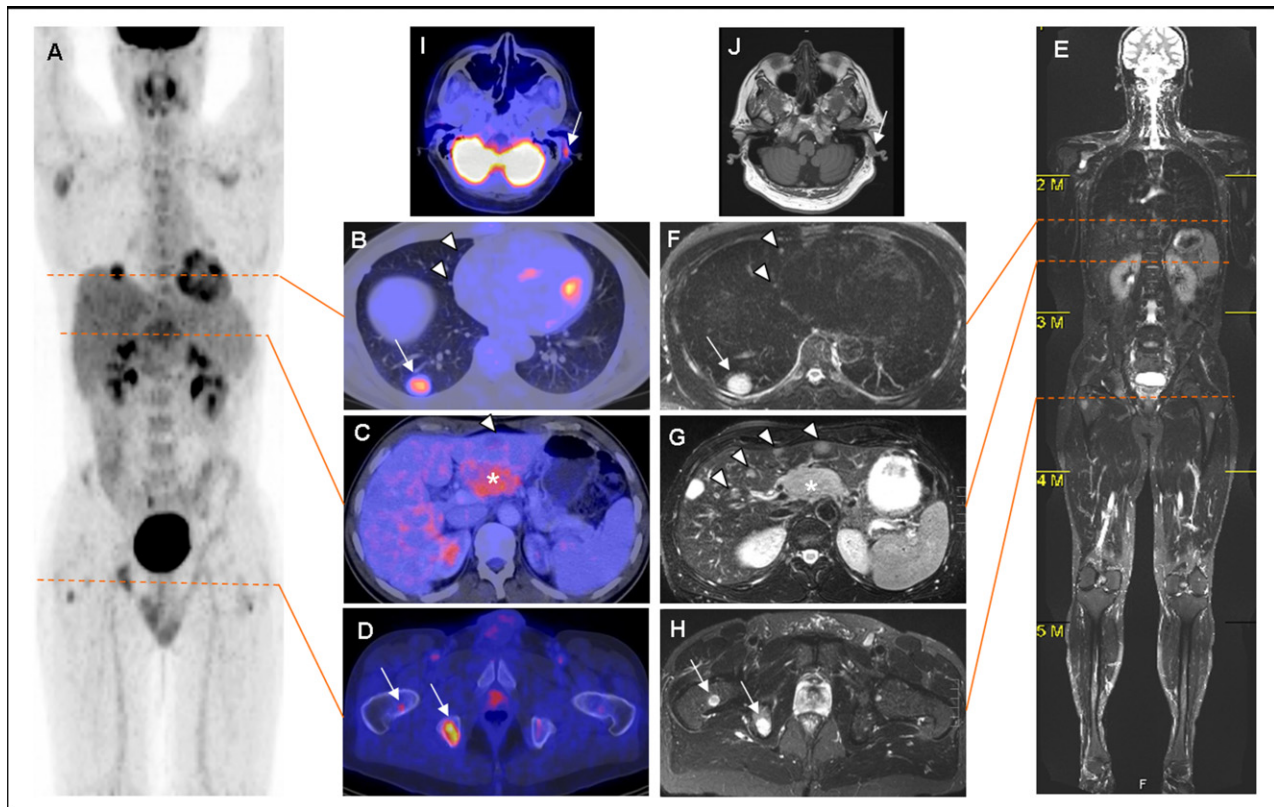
PET/CT (A–D) and wbMRI (E–H) of a 37-year-old male with metastatic melanoma. CT and MRI found more lung metastases than PET (B/F, arrowheads) and MRI found more liver lesions than PET/CT (C/G, arrowheads). Bone metastases were equally detected (D/H, arrows). The nodal metastasis behind the left auricle (I/J, arrows) was detected by PET only.
